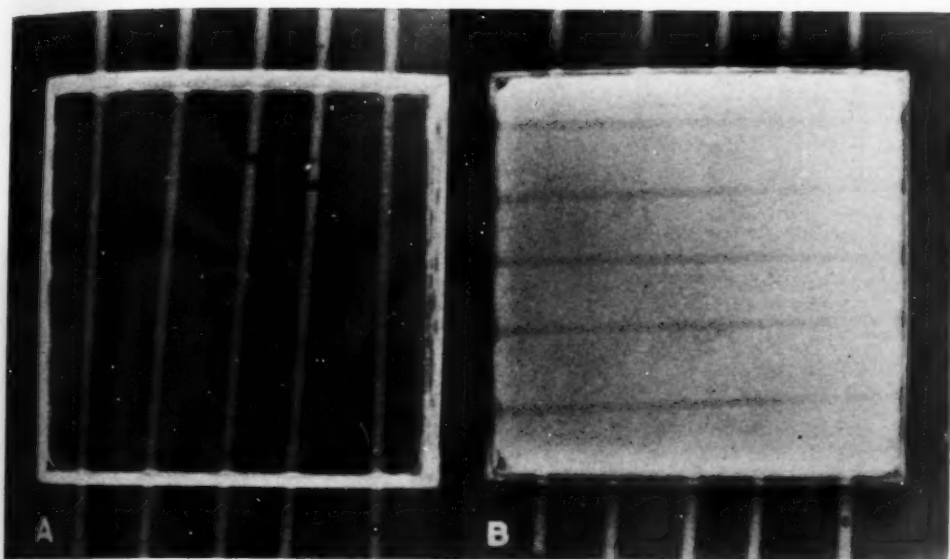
A. Roentgenogram of the box of Figure 1. The paraffin-filled straws stand out as white bands; the empty straws are invisible except for faint hairlines cast by their delicate walls.
